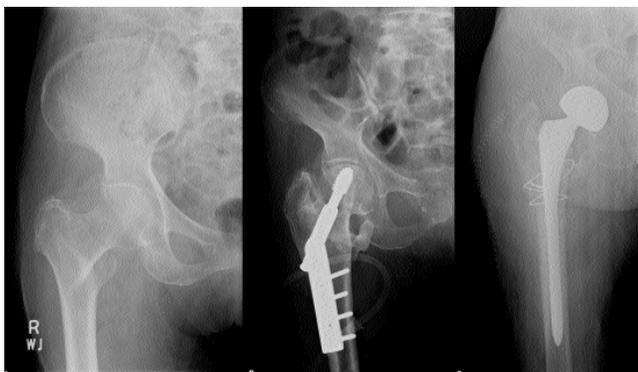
A. Plain radiograph of a 75-year-old lady showing an Evans type 3 intertrochanteric fracture of right femur. B. Plain radiograph of the same patient taken 28 months post-surgery showing avascular necrosis of the head of right femur. C. A plain radiograph obtained after total hip replacement procedure shows appropriate alignment.
